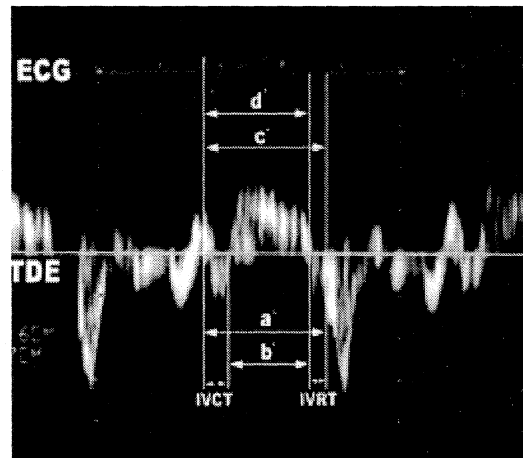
Tissue Doppler imaging of tricuspid annulus and time intervals
